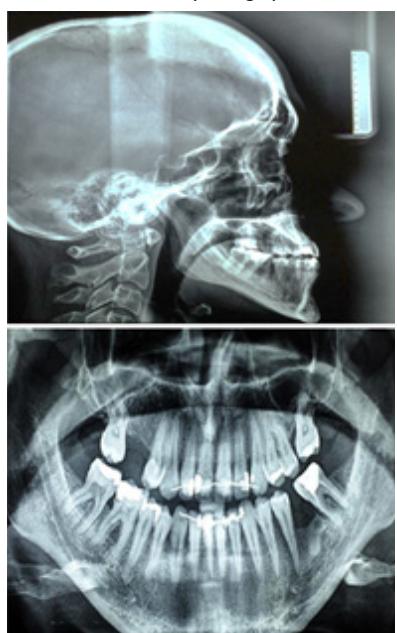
Post-treatment lateral cephalogram and panoramic radiographs.
